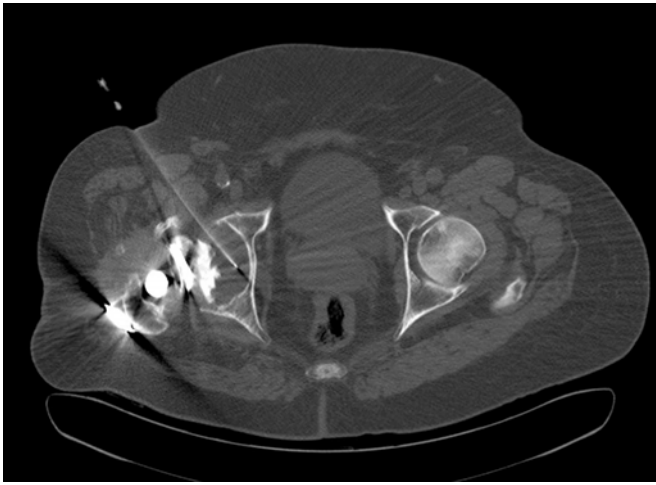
An 79-year-old man with surgical confirmation of infected right hip prosthesis (*Staphylococcus epidermidis*). Axial CT image allowed confirming placement of the needle in the middle of the prosthetic fluid. Positive cultures to *Staphylococcus epidermidis* were obtained on CT-Aspiration.
